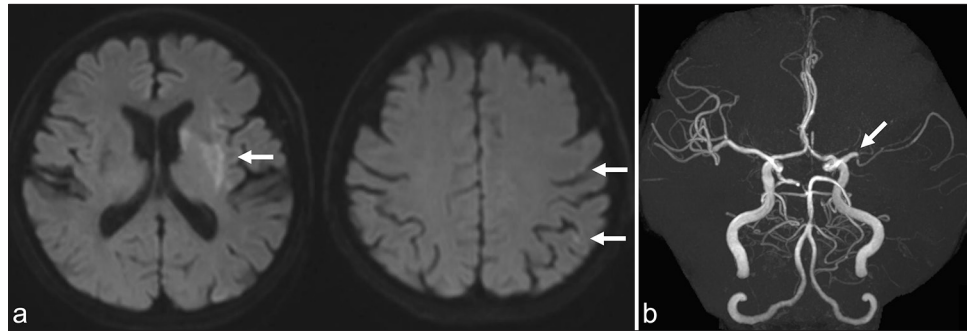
(a) Magnetic resonance imaging showing new infarcts in the territory of the middle cerebral artery (arrows). (b) Magnetic resonance angiography showing left middle cerebral artery occlusion (arrow).
